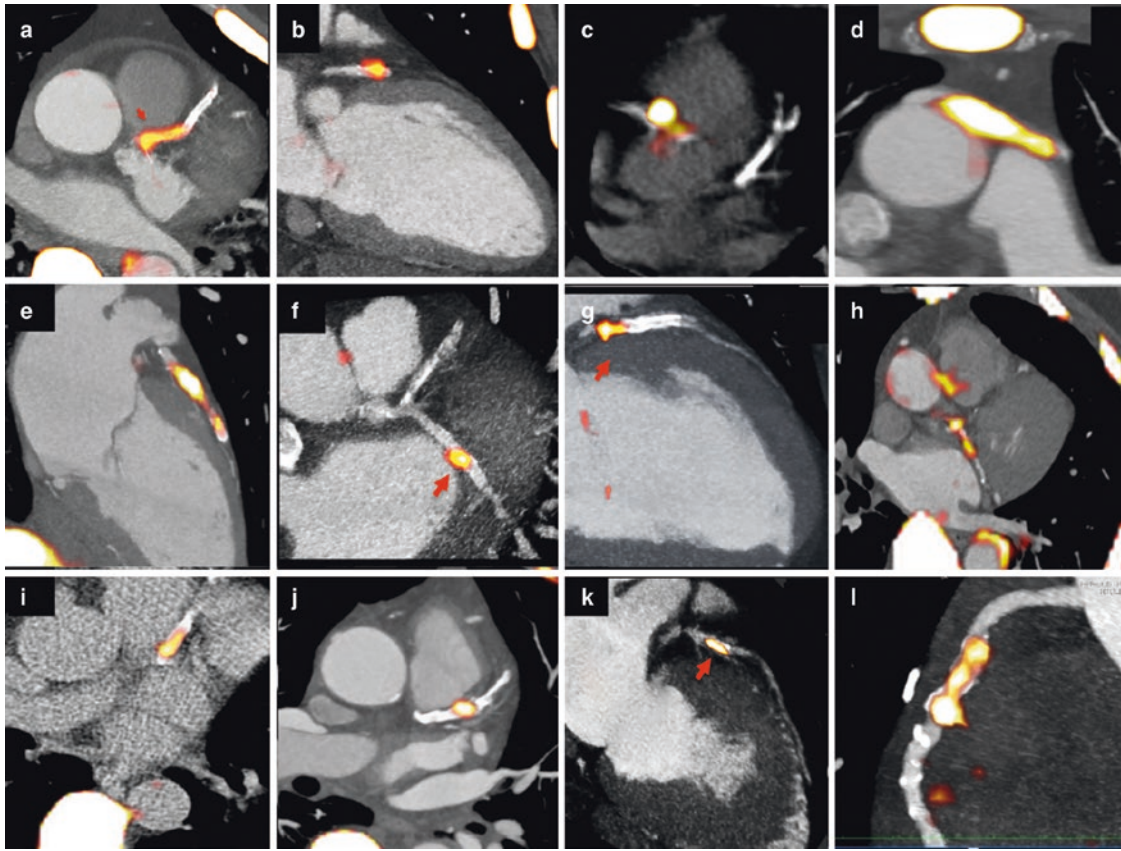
NaF PET-CT imaging of coronary microcalcification. Images demonstrate high focal coronary NaF uptake along different vessels from several patients, including the left anterior descending
